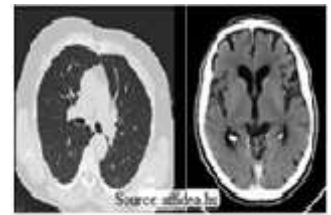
axial CT scans of the lungs and the brain
